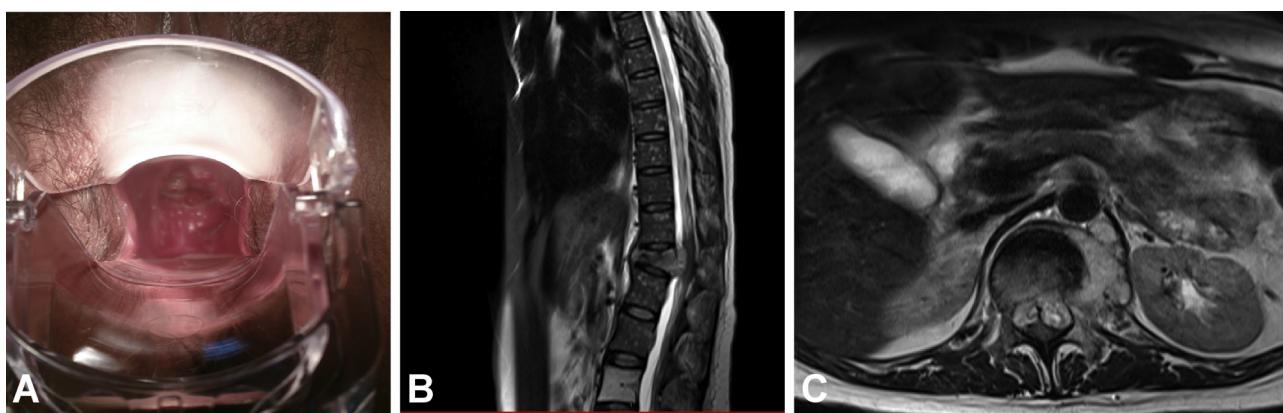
(A) Posterior speculoscopy at the start of external pelvic radiotherapy shows a clear reduction in tumor volume. (B) Magnetic resonance imaging (MRI) in the sagittal plane of the dorsal spine shows vertebral body metastasis with pathological fracture of the T12 vertebra. (C) MRI at the T12 level shows infiltrative metastatic compromise of the medullary canal.
